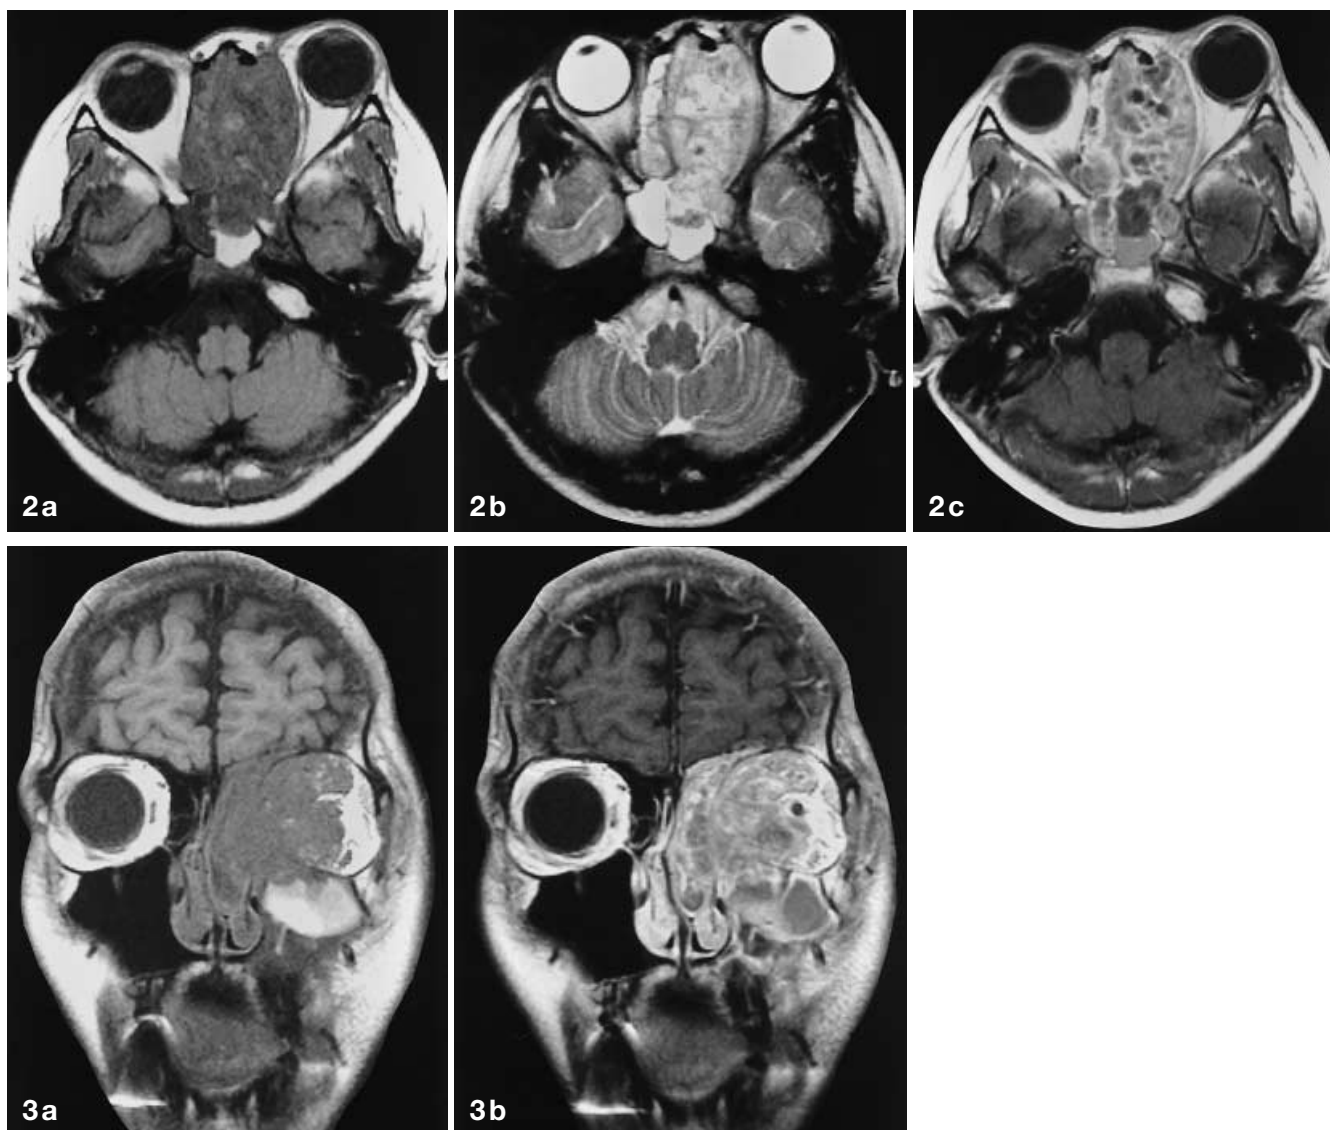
d Case 1: alveolar type maxillary rhabdomyosarcoma in a 6-year-old boy. a Axial T1-weighted. b T2-weighted. c Enhanced axial T1-weighted images at the same level. d Contrast-enhanced coronal T1-weighted image. The tumour occupies the right maxillary sinus, extends into the nasal cavity and ethmoid sinus, and has invaded the orbit. It is homogeneously isointense with muscle on the T1-weighted image, and gives heterogeneously high signal on the T2-weighted image. Grape-like enhancement (the “botryoid sign”) is seen in c and d
